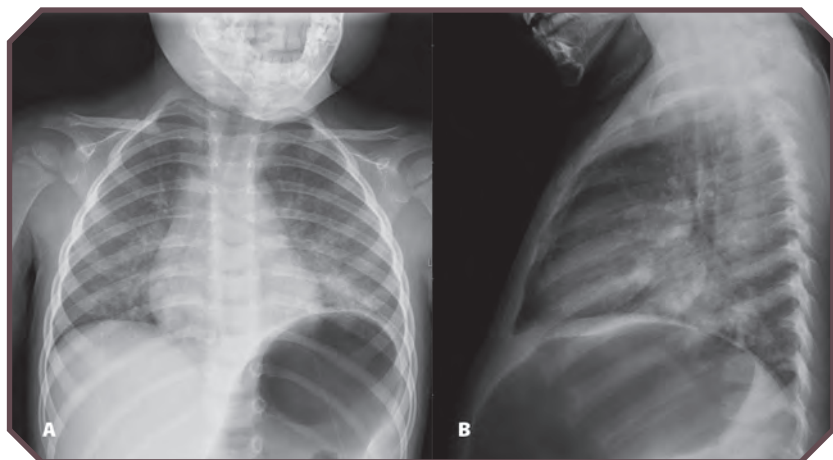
Hydrocarbon ingestion in a 2-year-old boy who drank furniture polish. A. Frontal and B. Lateral chest radiographs obtained 5 hours after presentation demonstrate left basilar and perihilar patchy opacities. (Not shown: The initial chest radiographic findings obtained 1 hour after ingestion were normal.)
